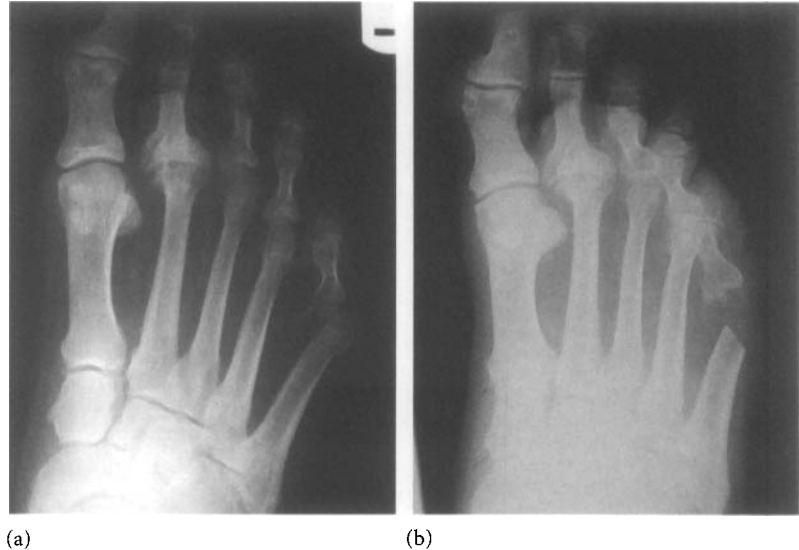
(a) Preoperative anteroposterior radiograph reveals deformity of the right 5th metatarsophalangeal joint with lateral bowing and prominence of the 5th metatarsal head. (b) Postoperative anteroposterior radiograph reveals resection of the 5th metatarsal head.
